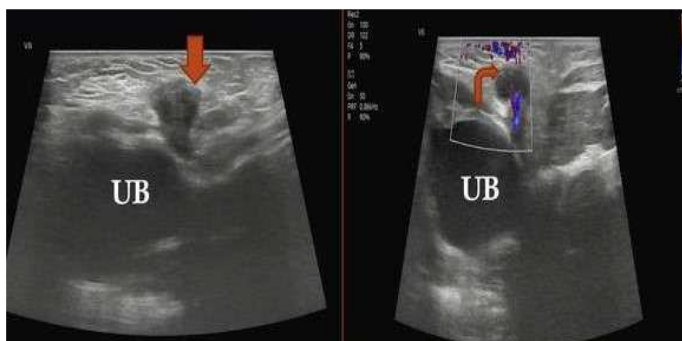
Color Doppler sonogram of a female infant groin swelling showing a left side indirect canal of Nuck hernia containing a round organ structure with cystic follicles verified as an herniated ovary.
